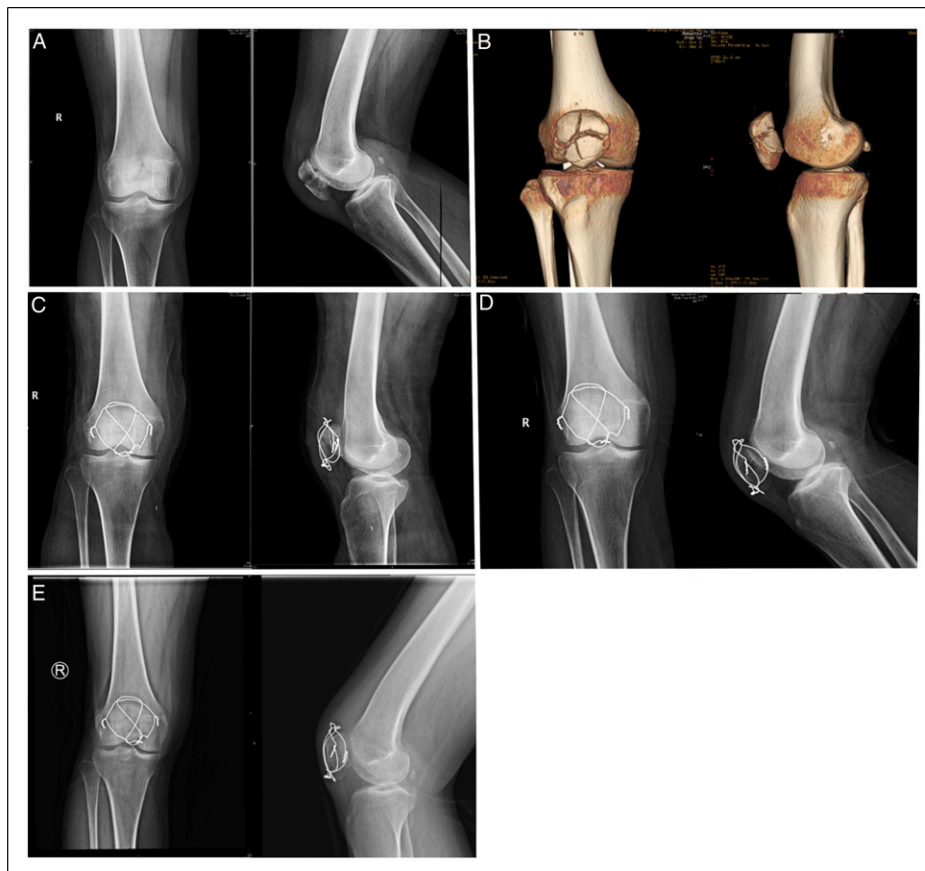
A 68-year-old male with a patellar fracture. (A) X-ray before surgery. (B) CT before surgery. (C) Post-fixation with modified cerclage wiring. (D and E) 3 months and 12 months after surgery.
